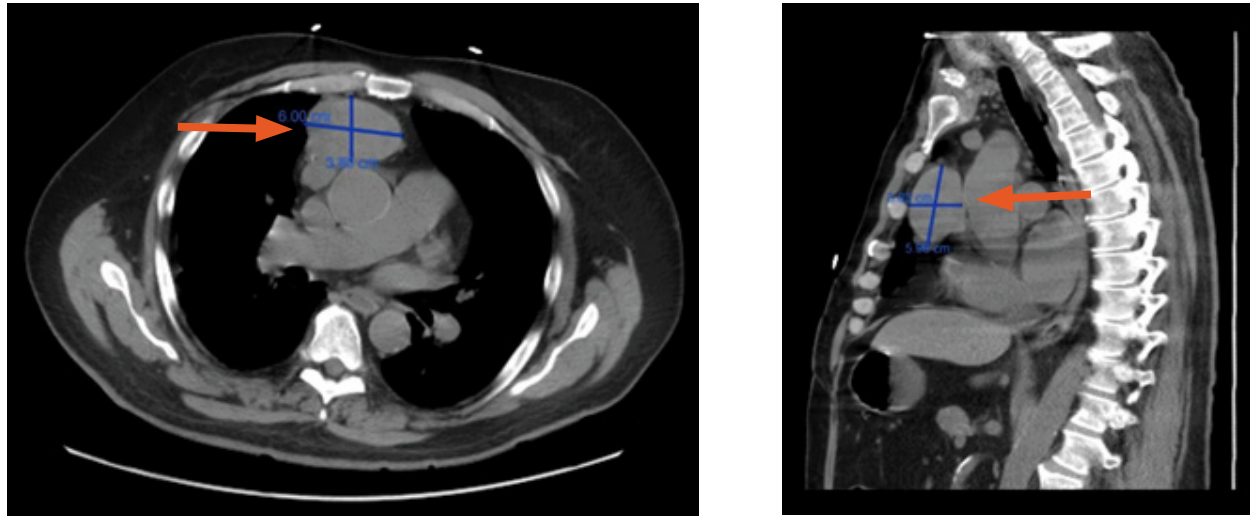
An initial chest CT scan without contrast shows an anterior mediastinal soft tissue mass measuring 3.8 cm x 6.0 cm in cross-sectional diameter abutting the ascending aorta posteriorly and the mediastinal pleura anteriorly (orange arrows).
